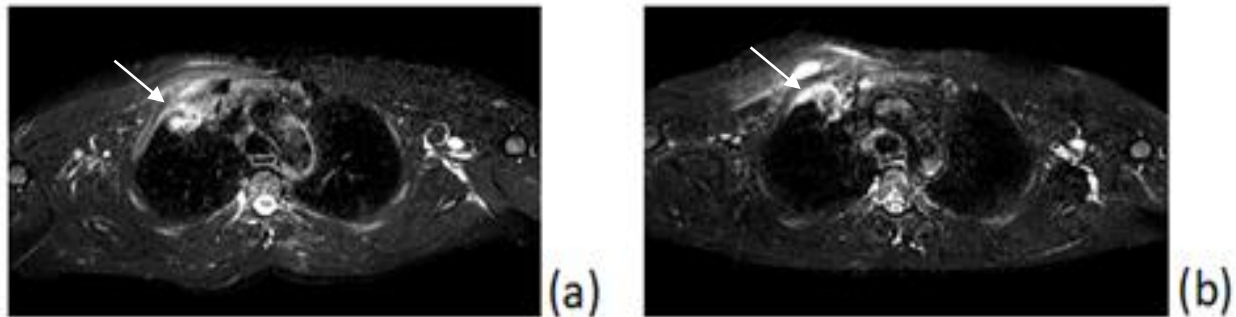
MRI identifying lung mass (arrow) before (a) and after (b) treatment
